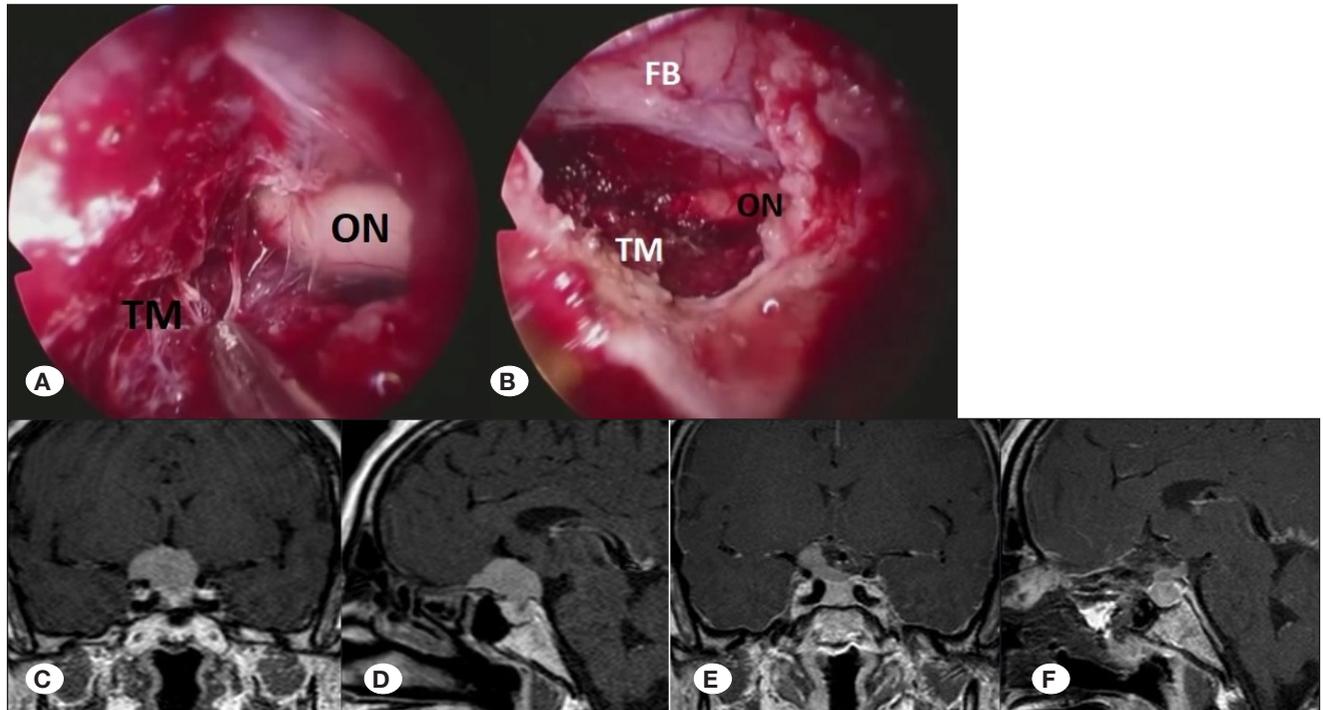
A) Intraoperative view of adherent and firm tumor B) Intraoperative view of adherent tumor before closure. Right optic canal invasion superior extension is seen. C) Preoperative coronal T1-contrast-enhanced MR image of patient in panel A D) Preoperative sagittal T1-contrast-enhanced MR image of patient in panel A E) Postoperative coronal T1-contrast-enhanced MR image of patient in panel A. Right optic canal invasion superior extension could not be evacuated. F) Postoperative sagittal T1-contrast-enhanced MR image of patient in panel A. ON: Optic nerve, TM: Tumor, FB: Frontal bazis.
